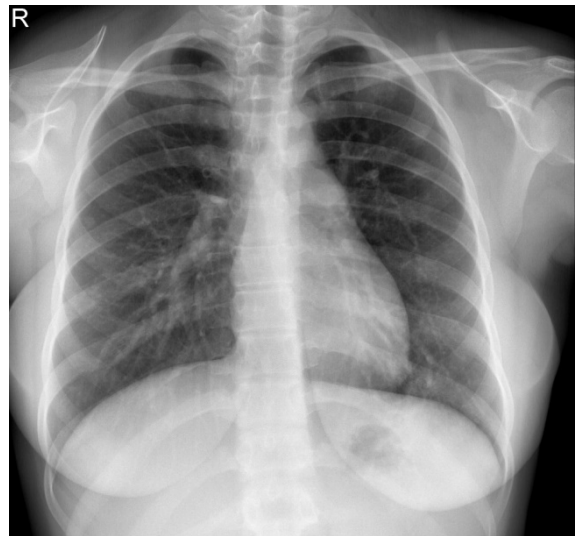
Follow-up chest X-ray after one year of treatment
